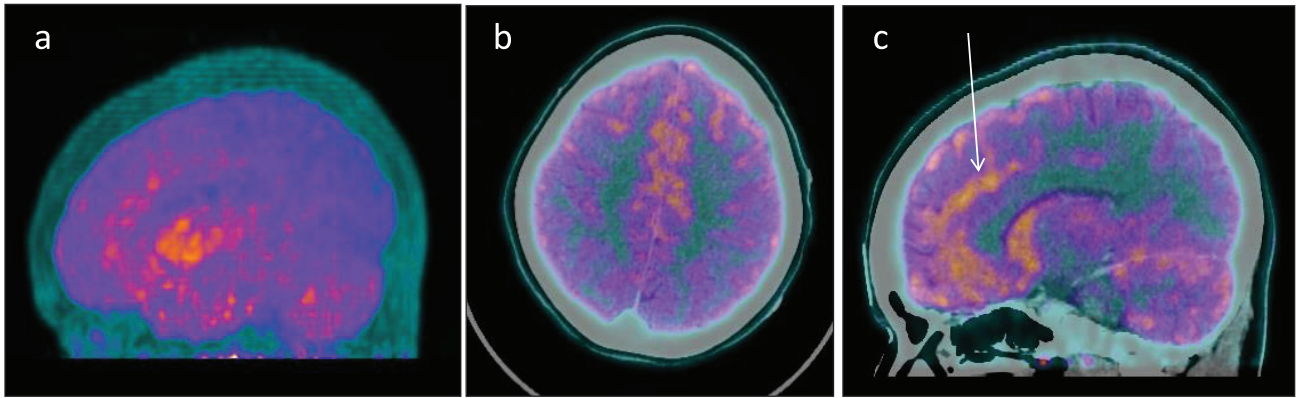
Shows 18F-FDG BRAIN PET CT MIP (a), Axial (b) and sagittal (c) section of fused PET/CT showing diffusely reduced FDG uptake in bilateral parieto-occipital regions. Bilateral frontal and temporal lobes show preserved/relative increased FDG uptake compared to parieto-occipital region, more so in medial frontal/anterior cingulate region (white arrow).
